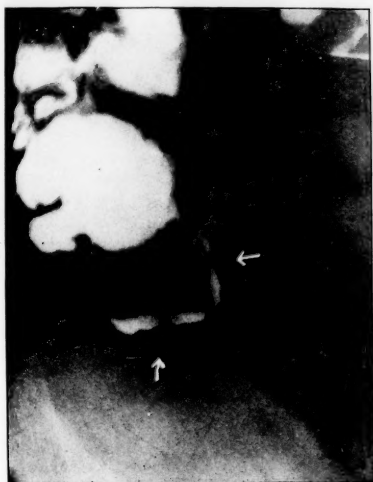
Appendix shows some fixation, angulation and beading, not tender. No operation; no symptoms for five years after x-ray examination.
